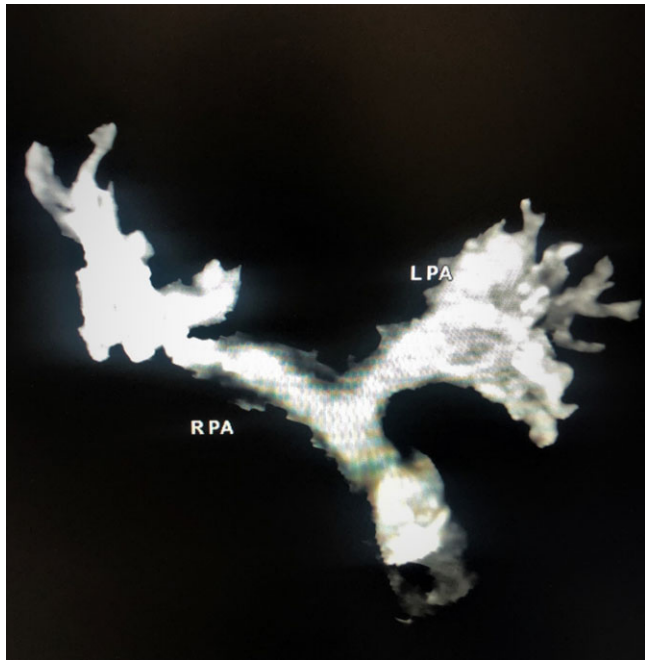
Three-dimensional CT revealing the hypoplastic right and left pulmonary arteries.
